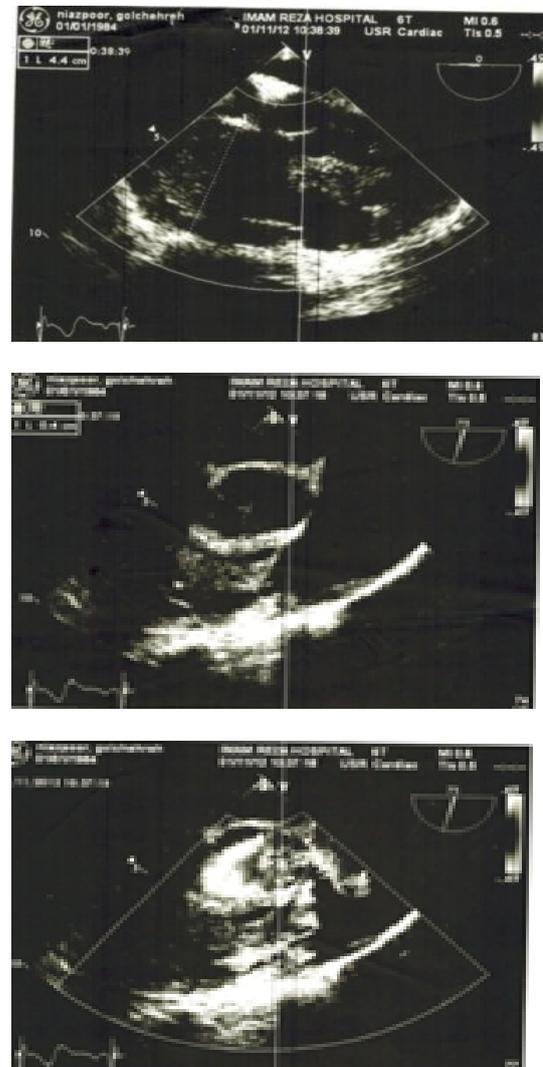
Echocardiographic pictures of right ventricle lymphangioma.
